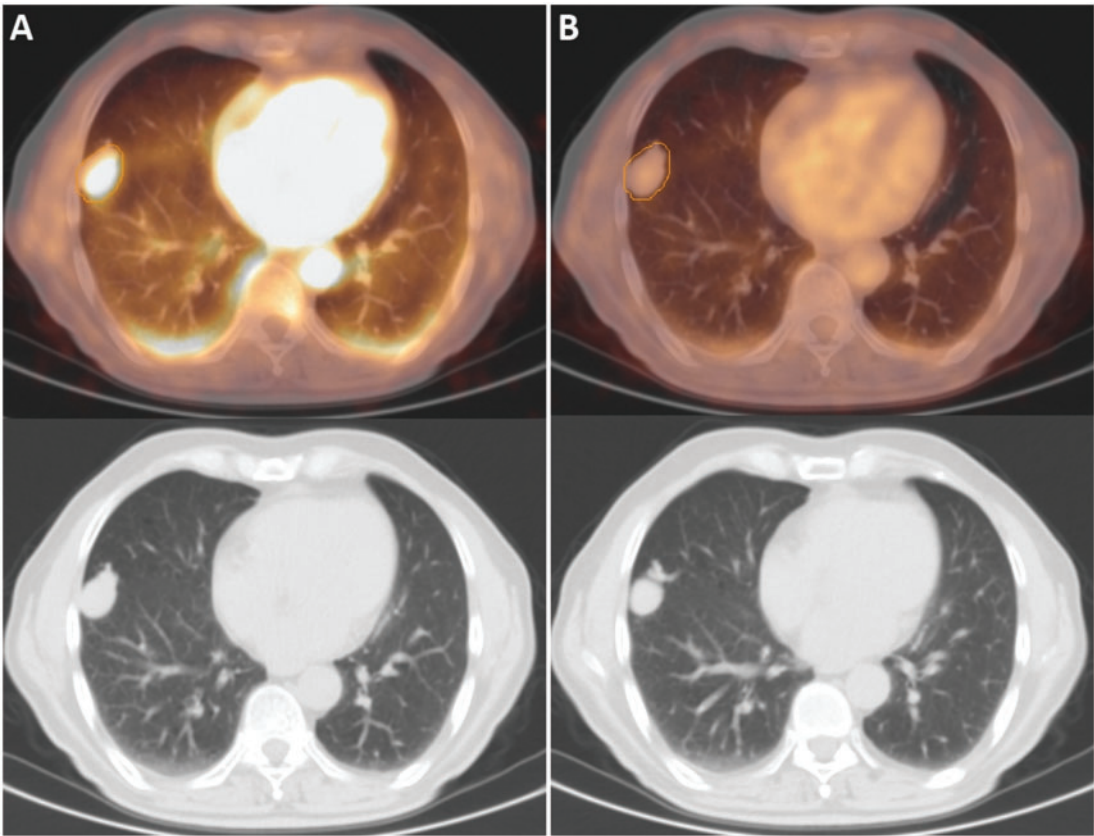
Axial fused PET/CT and CT images of the early dynamic FDG fluorodeoxyglucose positron emission tomography/computerized tomography (PET/CT) scan (A) showed increased FDG uptake (maximum standardized uptake value (SUVmax): 4.6) in a well-circumscribed right middle lobe nodule connected with blood vessels. Subsequent axial fused PET/CT and CT images of the late dynamic FDG PET/CT scan (B) demonstrated FDG washout (SUVmax: 2.2) in areas of solitary pulmonary nodule.
